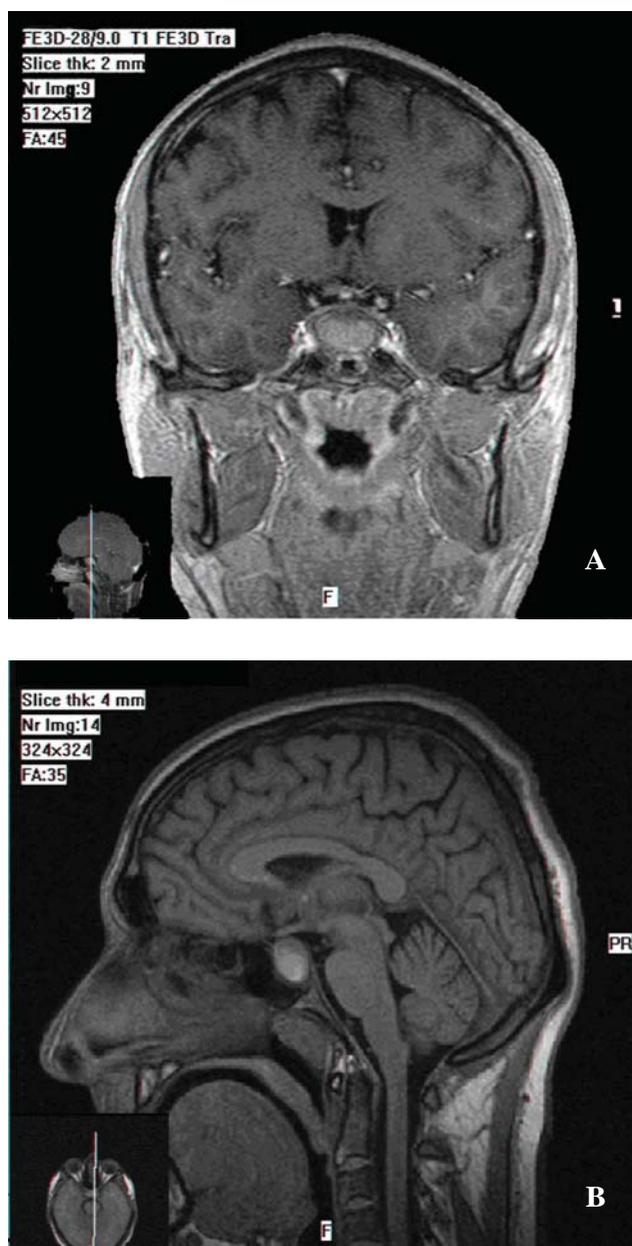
A, B. Magnetic resonance imaging of the pituitary gland showing the presence of an enlarged intrasellar mass with a central heterogeneous, slightly hyper-intense signal suggesting haemorrhage, which compresses the pituitary stalk and is tangent to the optic chiasm. 1A. shows coronal T1-weighted image and 1B shows mid-sagittal T1-weighted image of the pituitary gland.
